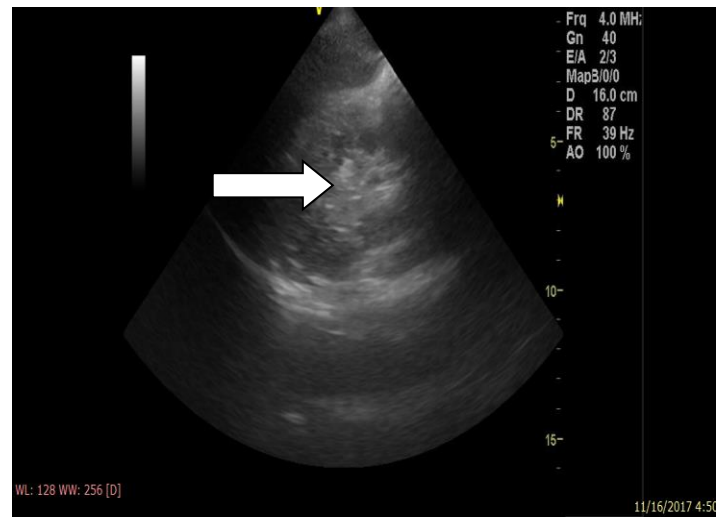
Longitudinal ultrasound scan image of a globular left kidney (white arrow) with diffuse echogenicity in a 45-year-old female with HIV-associated nephropathy.
